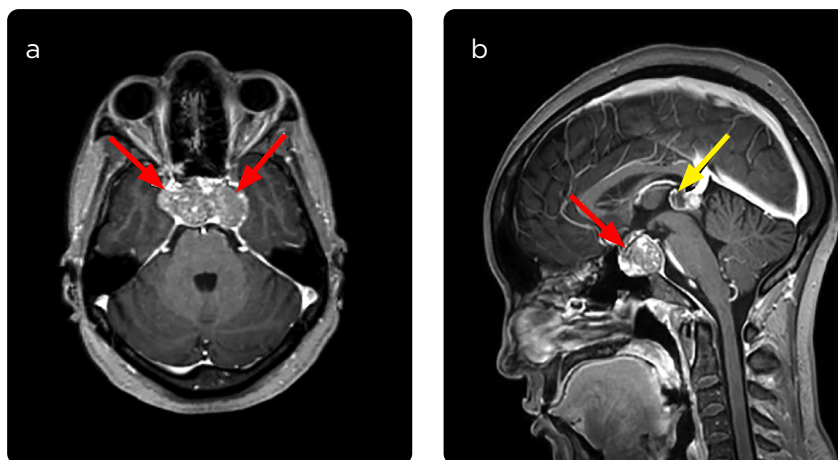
a and b) Magnetic resonance imaging of the skull, axial and sagittal sequences enhanced in T1 with gadolinium. Vascularized tumor in the sellar region (red arrows) and in the pineal region below the splenius of the corpus callosum (yellow arrow).
